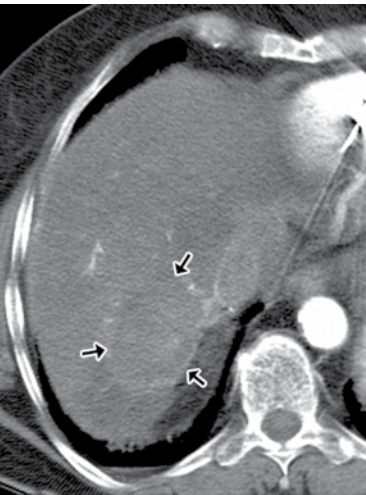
(c) Post-procedural CT scan obtained with contrast material enhancement shows a large area of thermo-coagulation (arrows).
